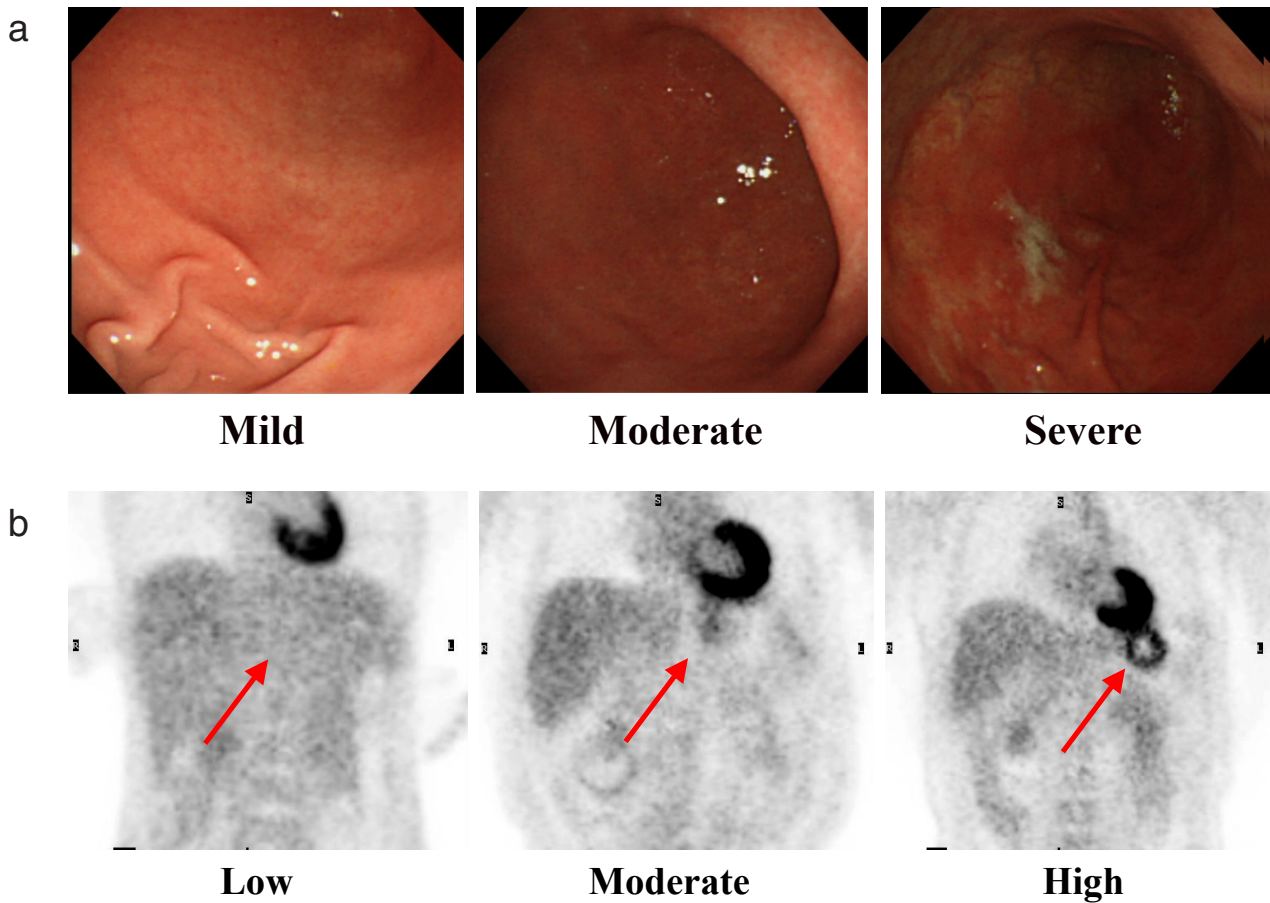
Classification of the severity of gastritis and the degree of gastritis. (a) The severity of gastritis was classified as mild, moderate, or severe according to the endoscopic appearance. (b) The degree of FDG uptake on PET images was classified visually as low, moderate, or high.
